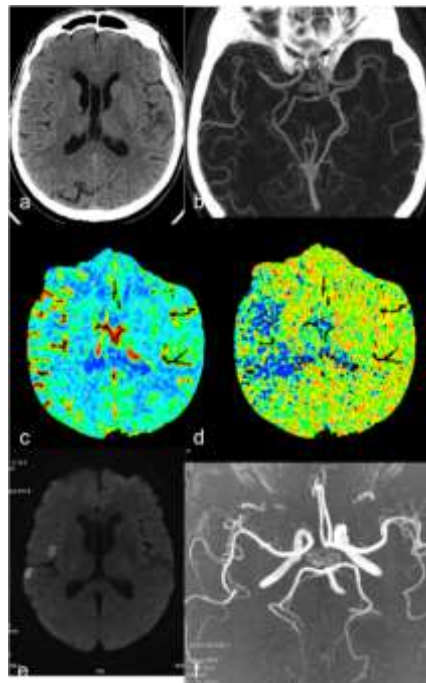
CTP evaluation of penumbra. Patient with acute onset of left hemiplegia and unremarkable NCCT (a). CTA (b) reveals thrombotic obstruction of the bifurcation of the right middle cerebral artery with good collaterals for the backfilling of distal vessels. CTP maps display a normal or slightly increased CBV (c) that corresponds to an increased MTT (d) in the middle cerebral artery territory and indicates penumbra with salvageable tissue if re-perfused. No clear ischemic core is identifiable. After recanalization, DWI (e) demonstrates only small foci of cytotoxic oedema within preserved middle cerebral artery territory. MRA (f) confirms the complete recanalization of the intracranial vessels.
